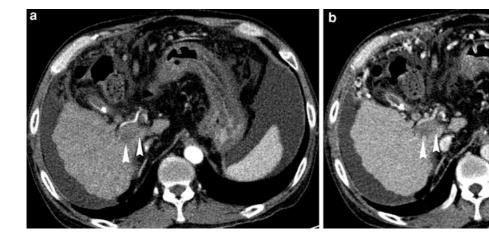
Liver cirrhosis with benign portal vein thrombosis. a Arterial phase CT scan shows a hypoattenuated thrombus in the right lobar branch of the portal vein (*arrowheads*). b Portal
